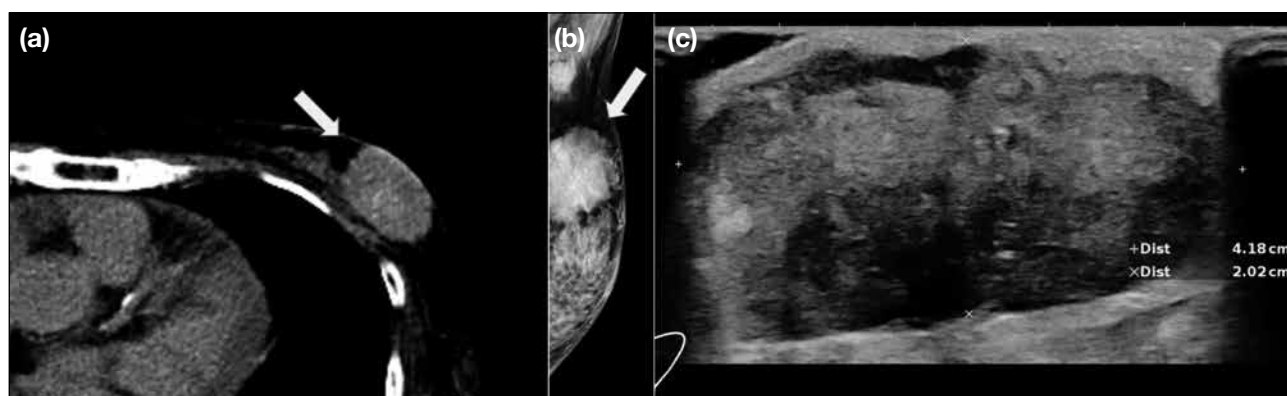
A 60-year-old woman with a contrast-enhanced computed tomography scan of the abdomen for abdominal pain. (a) An incidental breast mass with lobulated shaped and circumscribed margins is seen at the upper outer quadrant of the left breast with subtle internal calcifications (arrow). (b) Mammography showing a high-density, irregularly shaped mass with spiculated margins and internal pleomorphic calcifications (arrow). (c) Sonography showing the large left breast mass with internal echogenic foci suggestive of calcifications. This mass was later biopsied and confirmed to be invasive ductal carcinoma.
